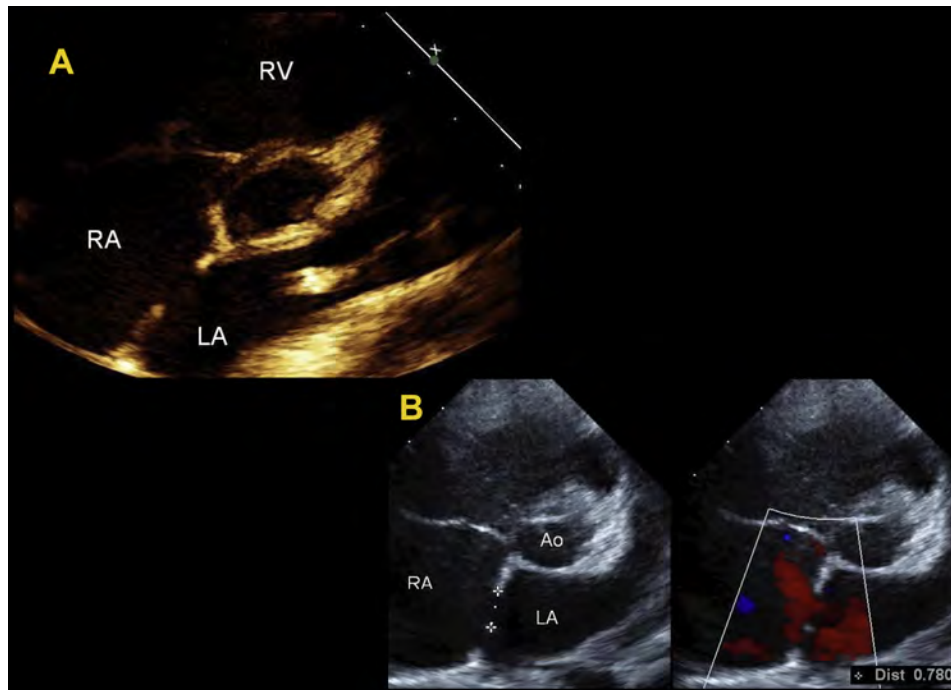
(A) Two-dimensional TTE of ostium secundum ASD from parasternal short-axis view. (B) Two-dimensional TTE (*left*) and with color Doppler (*right*) of an ostium secundum ASD from the parasternal short-axis view with measurement of the diameter in the anterior–posterior orientation and left to right flow by color Doppler. Ao, aortic root.
